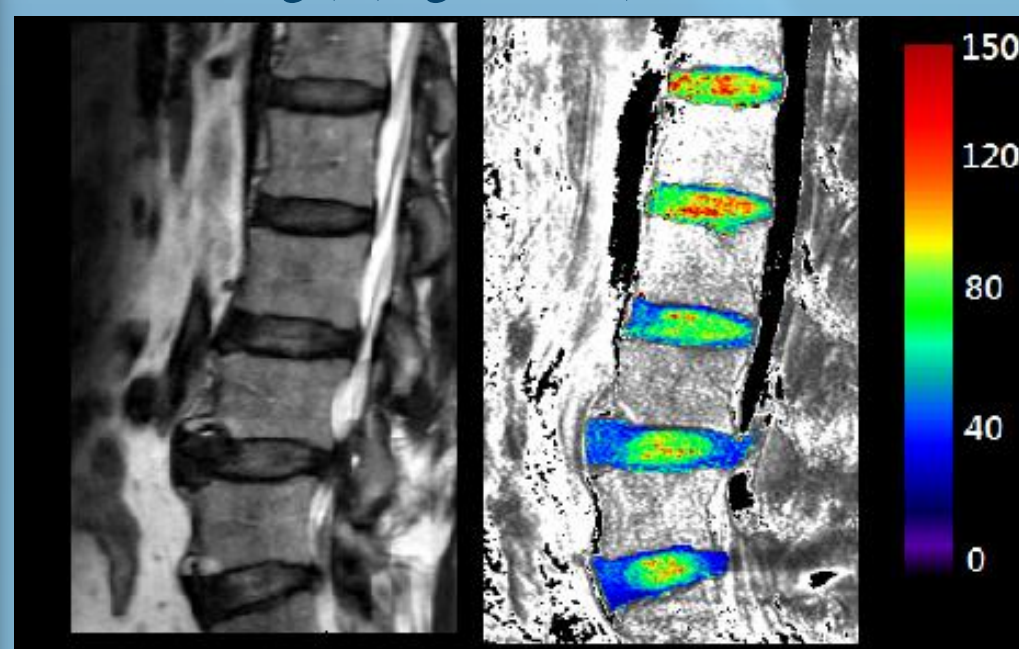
Disc degeneration was detected at lower levels of this patient, who also had disc degeneration at the same levels (Left: Conventional T2-weight MRI on spine. Right: T1 rho MRI mapping on color scale. Red / Yellow means higher T1 rho value. Green / Blue means lower value)
